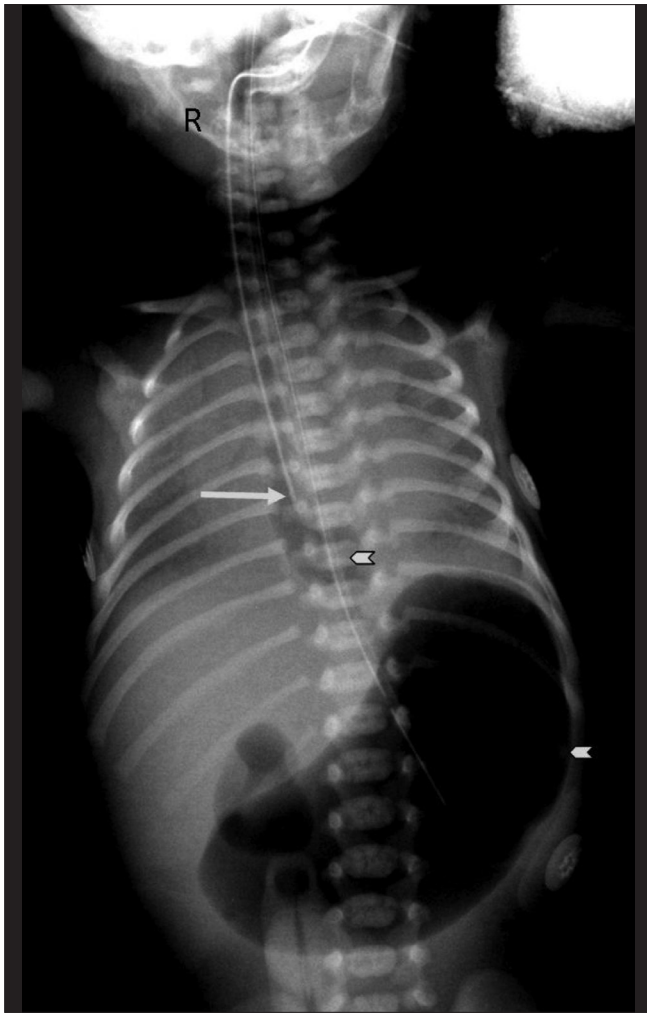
Frontal radiograph of a neonate shows inadvertent placement of an endotracheal tube in the esophagus (arrow) with distension of the esophagus and stomach (arrowheads) with air
